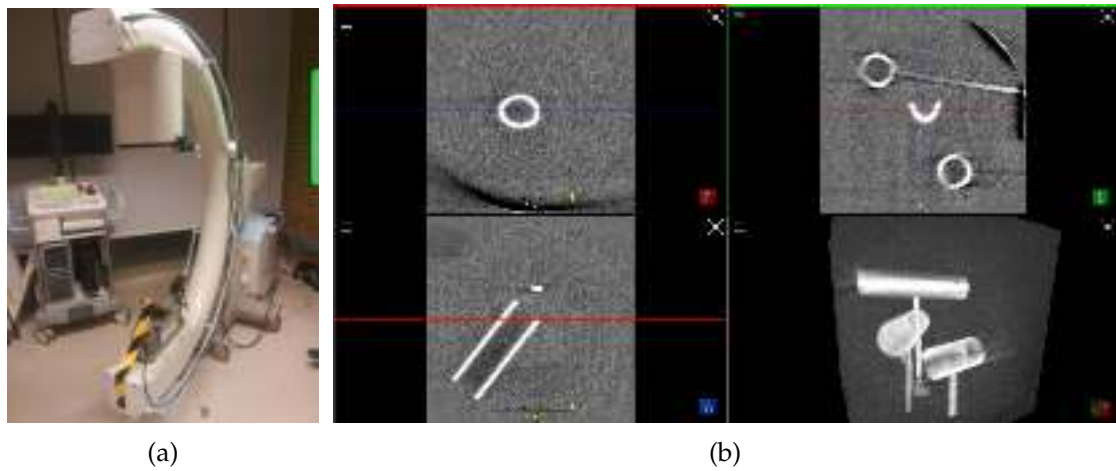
(a) The mobile C-arm device, and (b) the CBCT scanning result visualized in ImFusion SDK.
